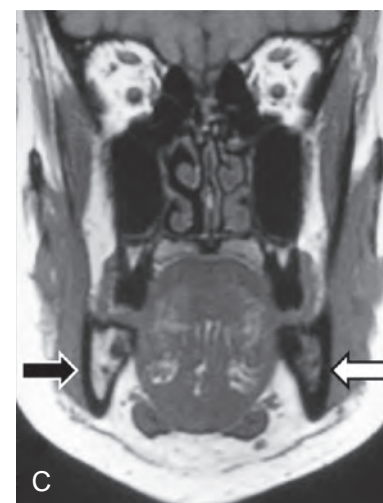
An axial view of a computed tomography scan of the oral cavity showing (A) an enhanced tumor of the right floor of the mouth in close proximity to the lingual plate of the mandible and (B) no obvious bone invasion on the bone algorithm (arrow points to lesion in A).
